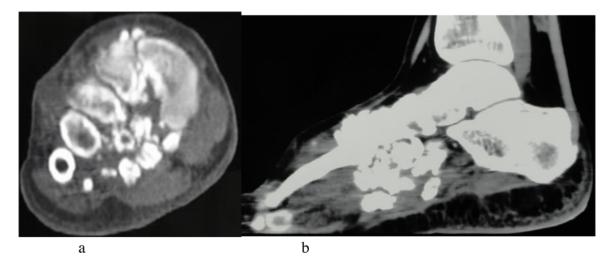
Bizarre parosteal osteochondromatous proliferation. CT (a,b) shows well-marginated wide based bony growths from midfoot, projecting into the soft tissues, with a lack of medullary involvement.
